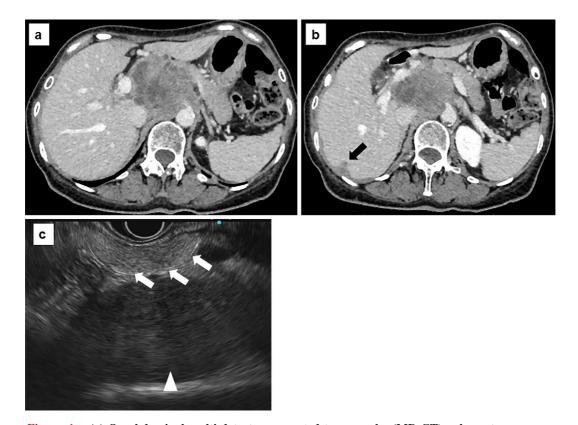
(a) On abdominal multi-detector computed tomography (MD-CT), a large tumor measuring 80 mm in diameter with internal necrosis on the dorsal side of the pancreas was observed. This tumor showed heterogenous enhancement and deeply invaded the surrounding blood vessels. (b) On MDCT, a tumor measuring 10 mm in diameter protruding from the outside on the surface of the liver was observed (black arrow). (c) On endoscopic ultrasound (EUS), a large hypoechoic mass on the dorsal side of pancreas was observed, and the border of the mass with the pancreas was clear (white arrows: pancreas, arrowheads: tumor).
